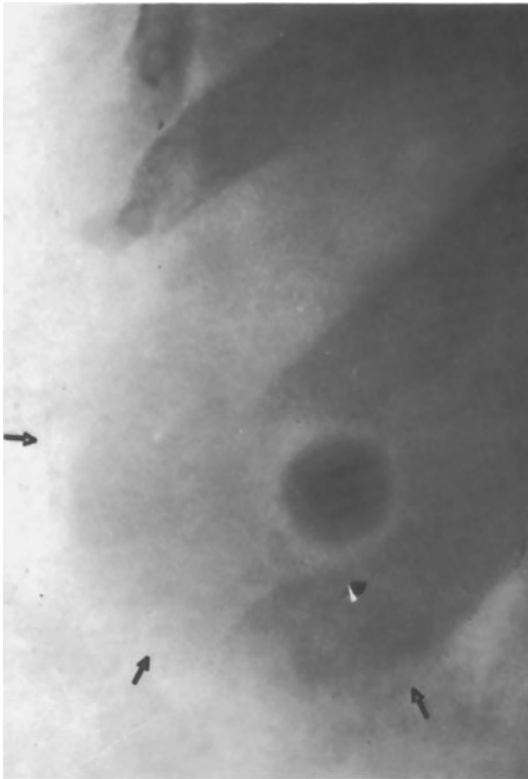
Hydrops of gallbladder (containing an opaque stone) visible on the plain film.
